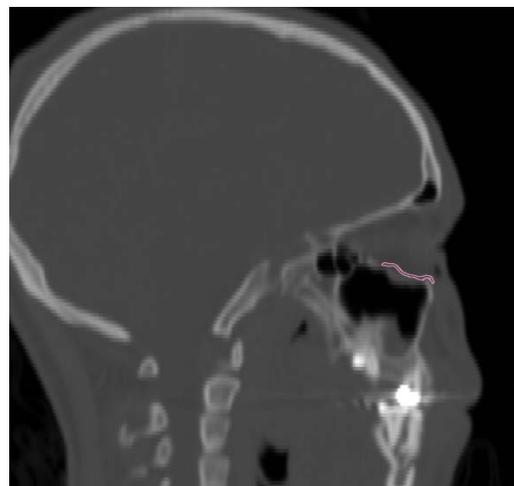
Radiographic picture the preoperative Virtual planning of the PEEK orbital sheet.
